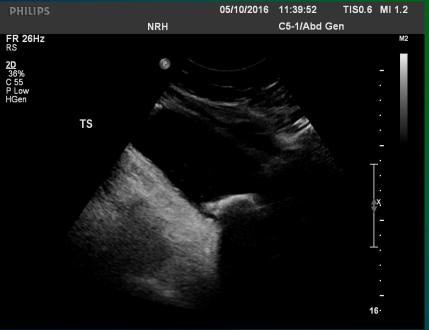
4 & 5 – Bladder stones with posterior shadowing clearly seen at US in distended bladder but not apparent on X-ray.
